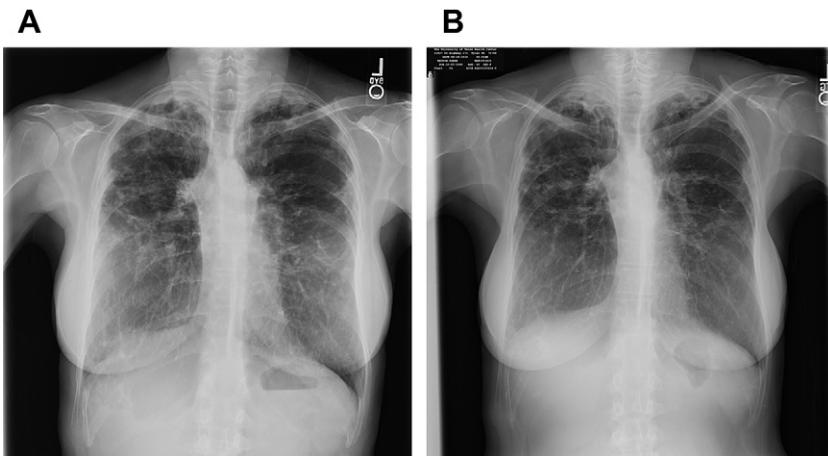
(A) P/A chest radiograph of a 62-year-old woman with bronchiectasis and one CFTR mutation and *Mycobacterium abscessus* lung disease, demonstrating bilateral nodular and reticulonodular densities in mid- and upper-lung fields. (B) P/A chest radiograph after 2 months of twice-daily nebulized hypertonic (7%) saline, showing improvement in the bilateral radiographic densities.
